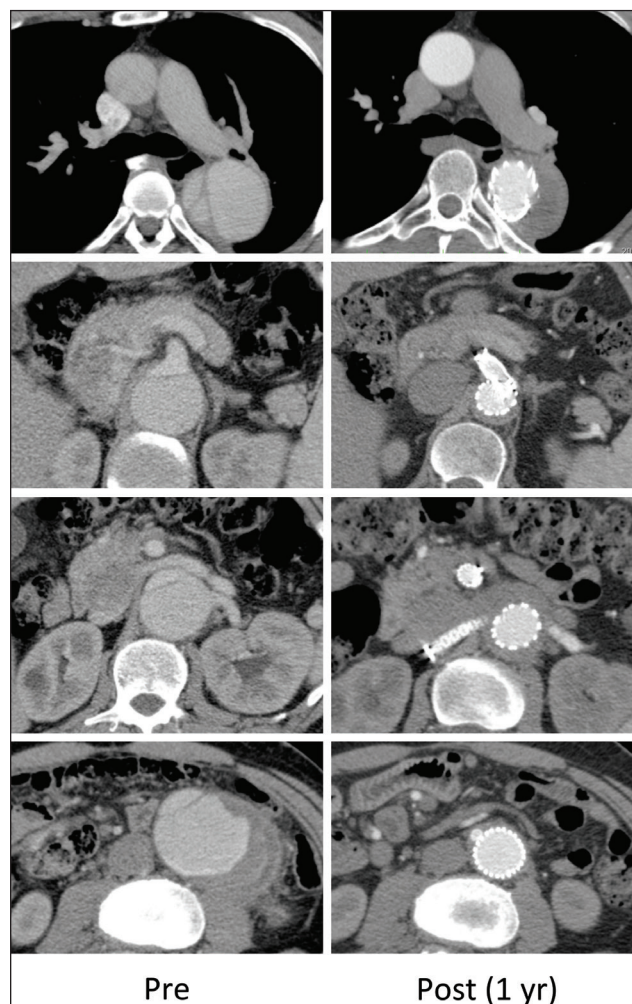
CT at preprocedure and 1 year after the total endovascular treatment for a chronic type B dissecting aneurysm. Note that the false lumen was thrombosed in the entire region of the dissected thoracoabdominal aorta and shrunk eventually 1 year after the thoracoabdominal endovascular treatment.
